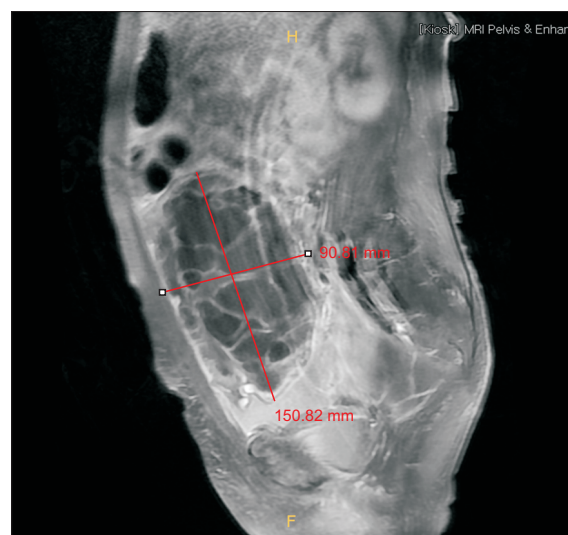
About 15 x 9 cm sized large multiloculated cystic mass with ascites, probable left ovary origin epithelial tumor (magnetic resonance image).
